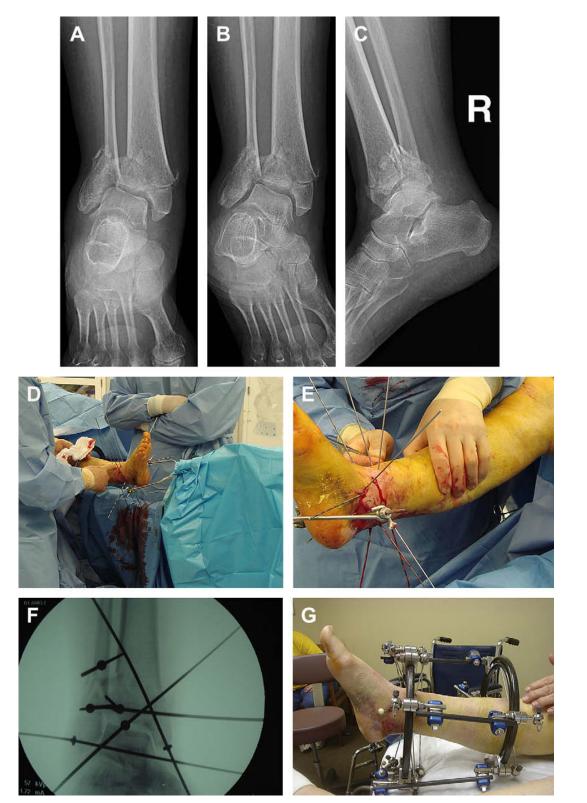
Preoperative anterior-posterior (*A*), medial oblique (*B*), and lateral (*C*) radiographic views show an intra-articular trimalleolar ankle fracture in a vascularly compromised diabetic patient. (*D*) Intraoperative views demonstrate the Bohler's clamp in the calcaneus with weight distraction off a fracture table aligning and reducing the fractures by means of ligamentotaxis. (*E*) Reduction olive wires are shown in place across the fracture fragments. (*F*) Intraoperative view shows anatomic reduction and ankle joint preservation with the use of multiple percutaneous tensioned olive wires. (*G*) Clinical picture at 3 weeks after surgery. The fixator was removed at 12 weeks. (*H–J*) Clinical views of dorsiflexion and plantarflexion at 6 months.
